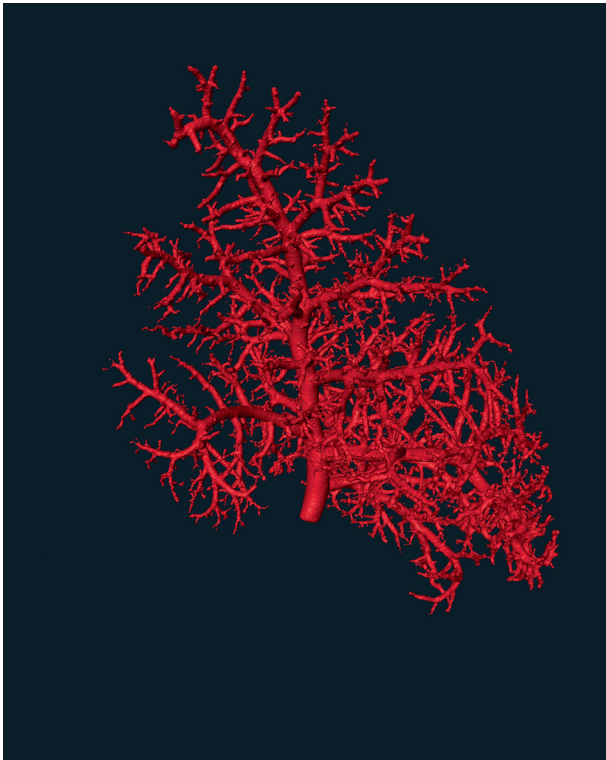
Summary of image processing. Top left: a single 2D image acquired during the computed tomography (CT) scan. Top right: a cross-section through the 3D reconstruction of the CT scan. Bottom left: Segmentation of a 3D scan to isolate the arterial tree from other lung structures. Bottom right: skeletonization of the 3D arterial tree to morphometrically analyze the structure by arterial generation number. Gray lines in the skeleton represent arteries, while yellow dots are the intersections between arteries or the endpoints of arteries
